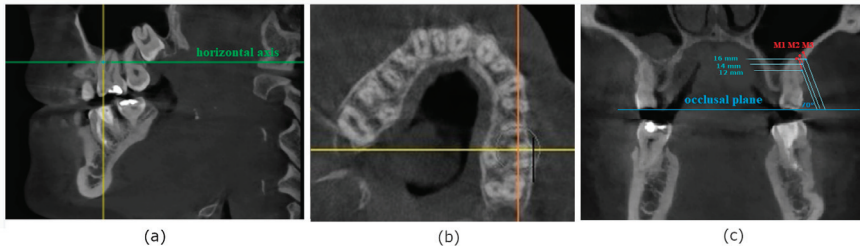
Measurement of bone depth on CBCT scans: (a)—sagittal slice consisting of mesio Buccal root of the first permanent molar used to obtain horizontal slice; (b)—horizontal view of the maxilla rotated in relation to the coronal axis to obtain a cross-section of the alveolar process at the level of M1; (c)—measurement of IZC thickness in modified coronal view.
